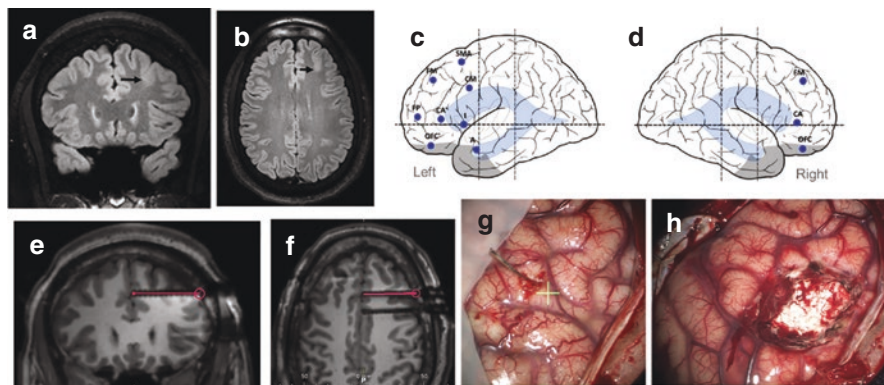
Clinical case of a 17-year-old boy, with seizures since 5 years of age, refractory to AED. Video-EEG was compatible with a frontal localization but failed to lateralize. (a and b) MRI scans showing mild blurring in the middle frontal gyrus, typical of “bottom of sulcus” dysplasia. A decision to explore with SEEG was made, using nine electrodes (c) on the left side and 3 (d) on the right side. (e and f) MRI scan showing the location of the electrodes related to the epileptogenic zone (EZ). (g and h) intraoperative images showing the electrodes in place (yellow arrow) and excision of the EZ. Pathology: cortical dysplasia type II b
